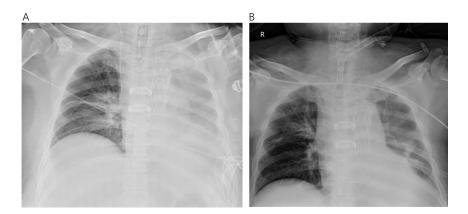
Prone position significantly improves chest X-ray imaging performance. Chest X-ray imaging showed that the diffuse shadow in left lung was significantly improved after prone position. A) Before prone position; B) after prone position.
